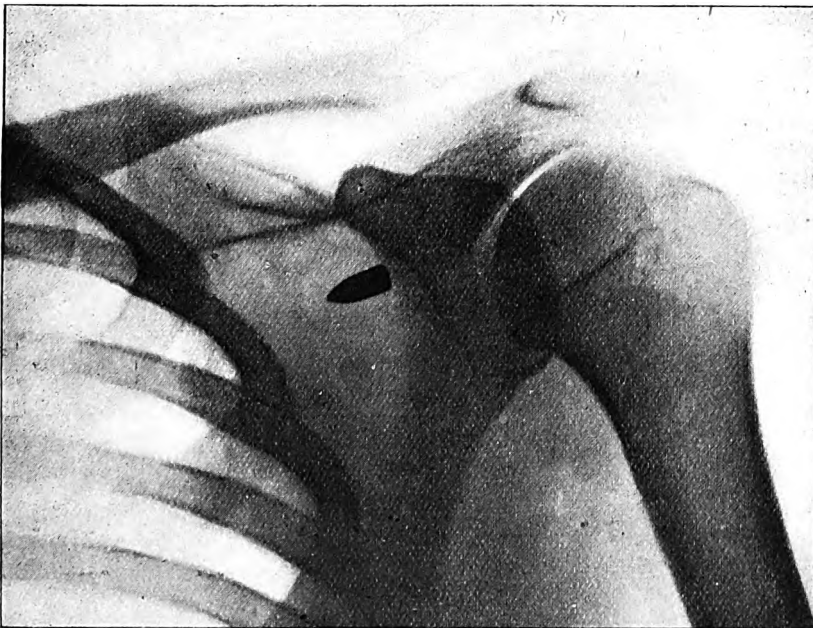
(*Case 2*).—Radiograph showing armour-piercing nose cap of tracer bullet superficial to the scapula.
